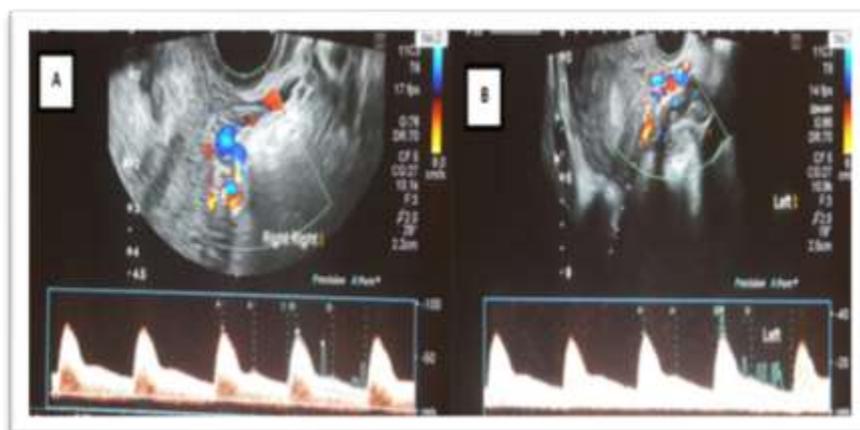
a, b Transvaginal Doppler ultrasound of both uterine arteries (a right, b left) of fertile female (control group) aged 25 years old shows RI of right and left uterine arteries were 0.58 and 0.58 with mean RI 0.58 and PI of right and left uterine arteries were 1.1 and 1.96 respectively with mean PI 1.53.[3]
